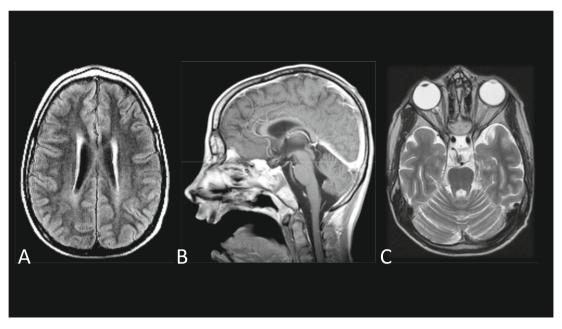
Cranial 1.5 T MRI at 14 years of age (A: axial FLAIR, B: sagittal T1 after contrast medium, C: axial T2). Subtle signs of periventricular leucomalacia (A) without any signs of brainstem or cerebellar abnormality (B, C) – especially no signs of pontocerebellar hypoplasia or of Joubert syndrome (no molar tooth sign).
